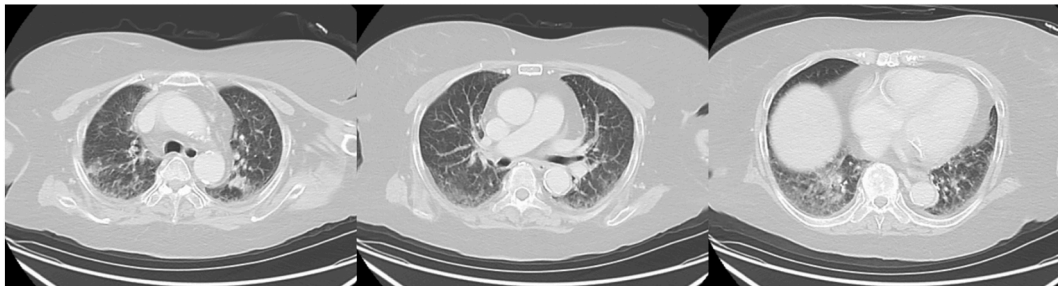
Findings of chest computed tomography (CT) on admission. Ground-glass opacities and infiltrative shadows in both the upper lobes and the right lower lobe.
